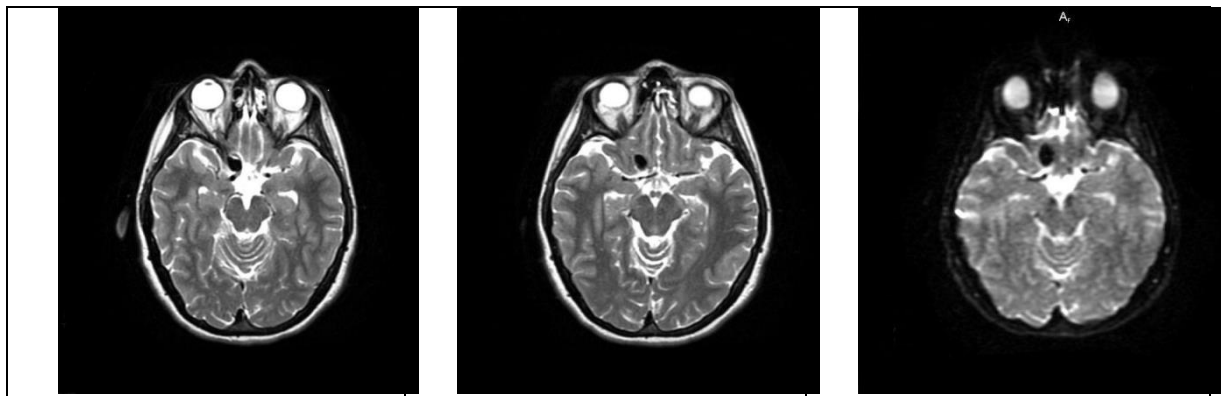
MRI investigation
